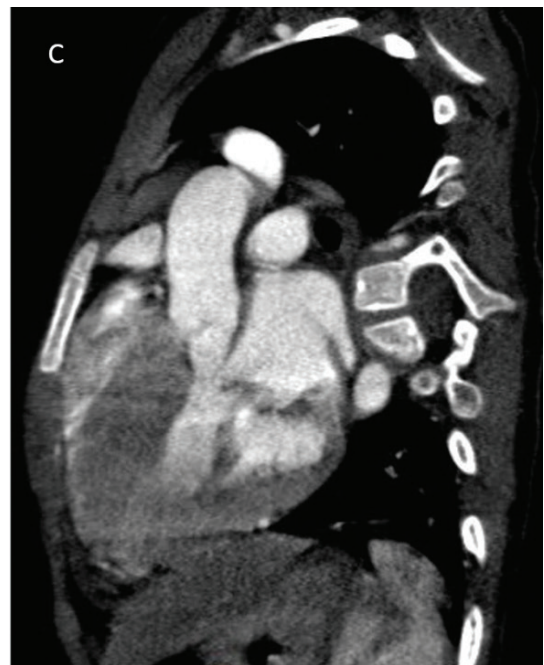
Preoperative CT (left ventricular outflow).
